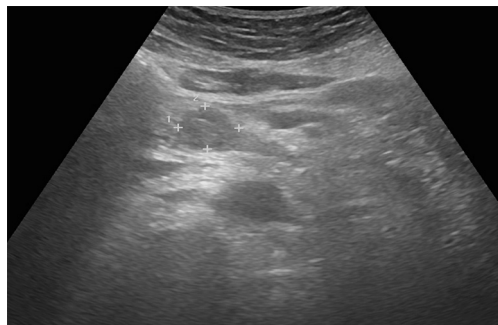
The duodenal glomus tumor shows a well-circumscribed hypoechoic mass on ultrasonography.
